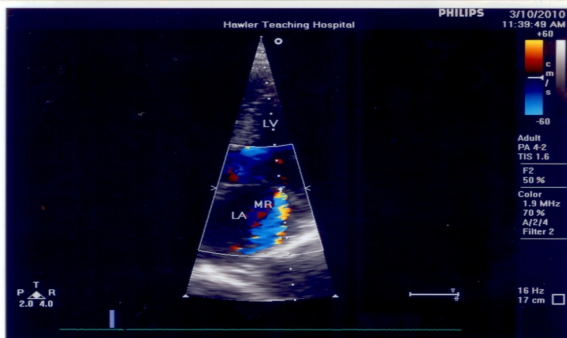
Apical four chamber view recorded from a patient with lateral mitral regurgitation. LV=left ventricle, MR=mitral regurgitation, LA= left atrium.
